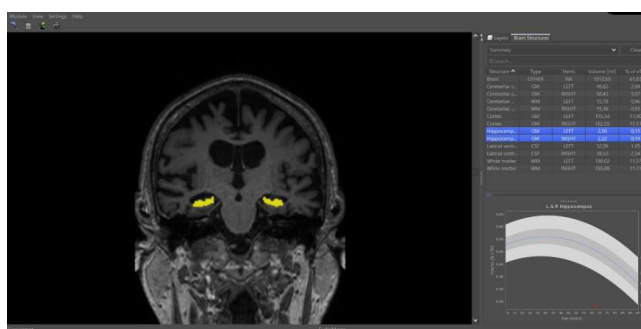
Example of structural Magnetic Resonance Imaging (MRI) [24].
